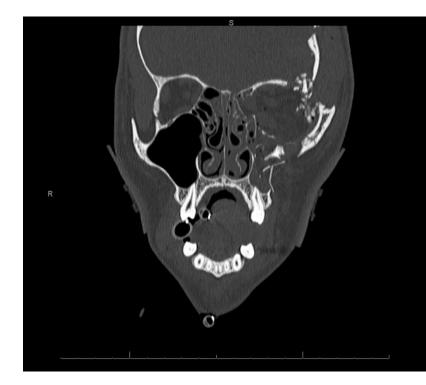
Coronal (A), sagittal (B), and axial (C) CT maxillofacial images from a patient with bullet wound to the left orbit causing complete destruction of the orbit. Patient was also noted to have traumatic avulsion of the optic nerve, pre-retinal hemorrhages, and intracranial bleeding.
